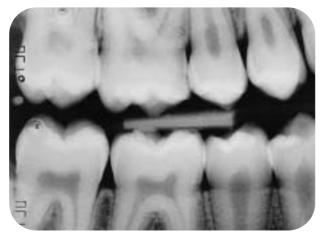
above,* bitewing radiograph of right upper and lower molar and premolar teeth. Plate 2, *right,* periapical radiograph of upper right premolars and first molar. 654 or 14, 15, 16.
